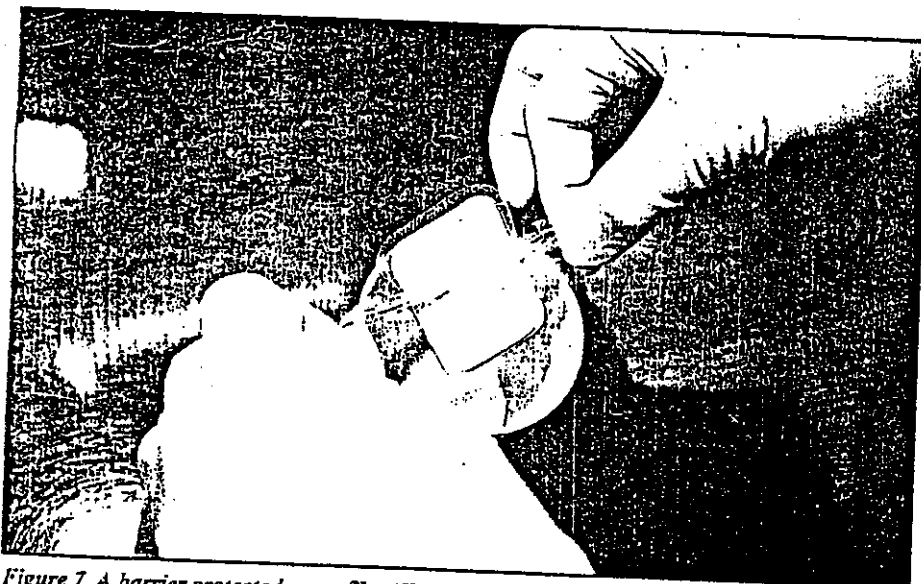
A barrier protected x-ray film (Kodak ClinAsept Barrier Envelopes, Eastman Kodak Co, Rochester, NY) prevents contact between oral fluids and the film packet.
